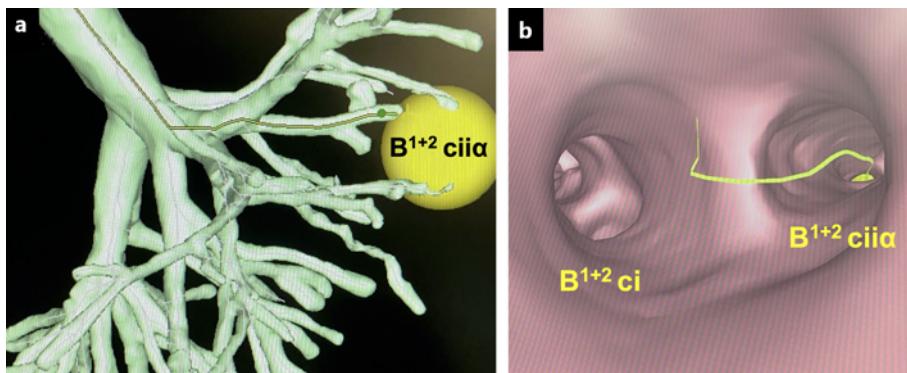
Virtual bronchoscopic images of the patient with lung adenocarcinoma. The tracking line (yellow line) is drawn to the target lesion (yellow circle). a The oblique view of the bronchial tree is reconstructed from the data obtained from the thin-slice CT, indicating the route to the lesion through the left $\text{B}^{1+2}\text{ cii}\alpha$. b The endoscopic view is also created, showing the orifice of the $\text{B}^{1+2}\text{ cii}\alpha$.
